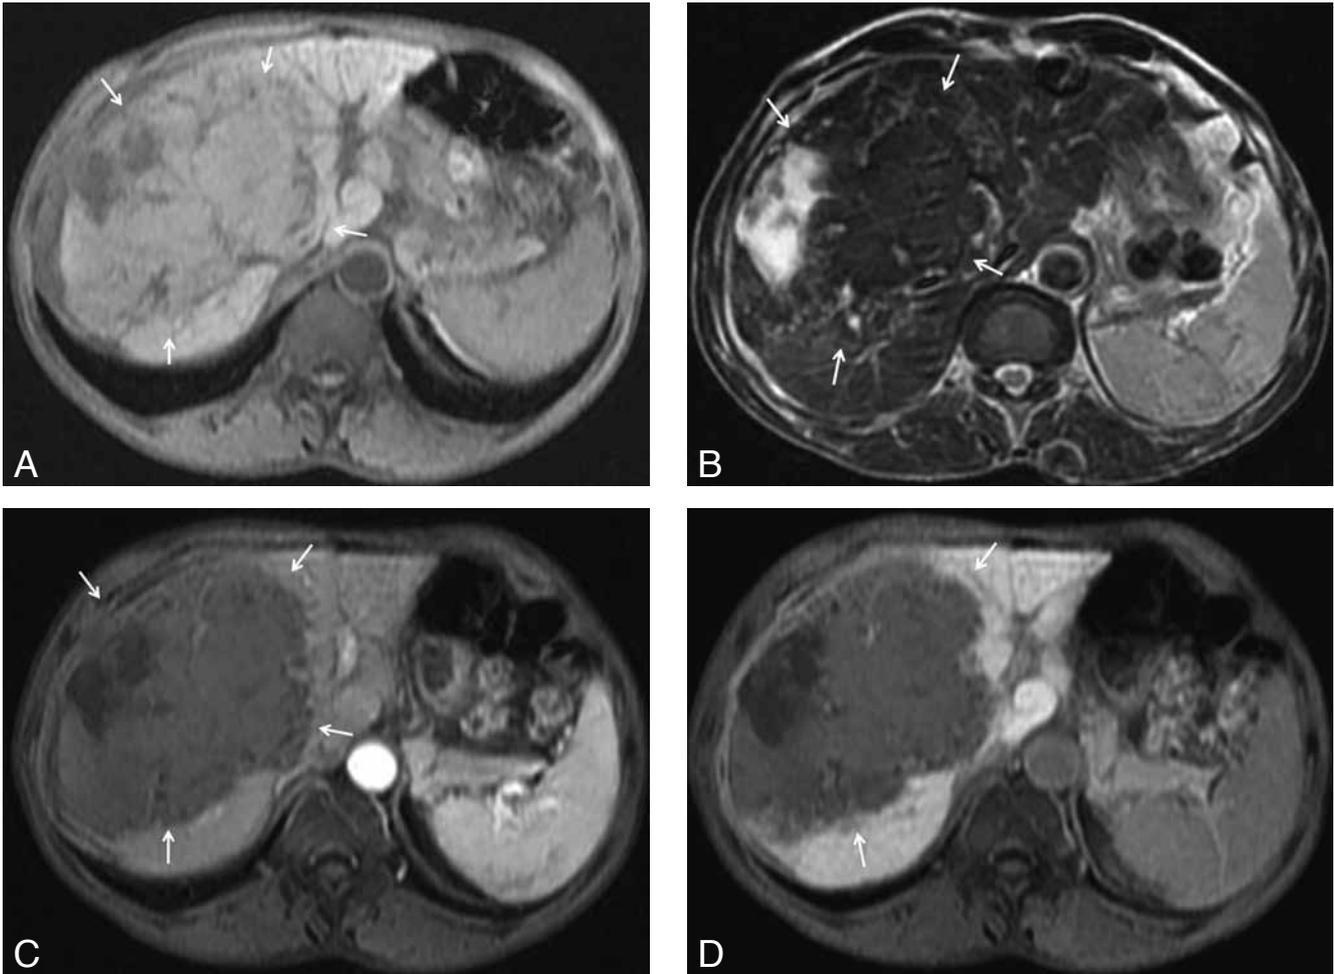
On T1-weighted (A) and T2-weighted (B) MR images the mass shows heterogenous signal intensity. On T1-weighted MR images obtained after intravenous administration of gadolinium-containing hepatocyte specific contrast material (C), the mass does not enhance in the arterial phase. On images obtained during the hepatobiliary phase (D), there is no enhancement. neither.
